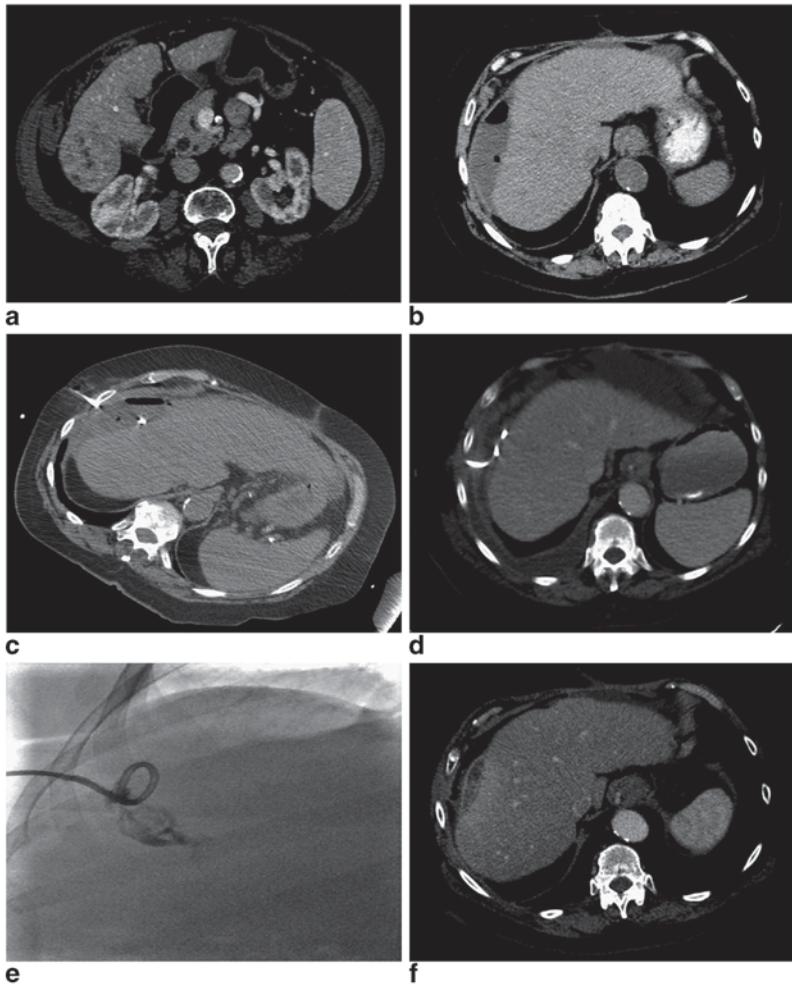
A 68-year-old female with history of cirrhosis secondary to NASH and alcoholism, Child Pugh class A, insulin-dependent diabetes mellitus, and coronary artery disease who presented with a 5.6 cm arterially enhancing exophytic mass in segment 6 of the liver with portal venous washout consistent with hepatocellular carcinoma (a). The patient underwent an uneventful nonanatomic wedge resection, which revealed a well-differentiated HCC without vascular invasion. Her postoperative course was remarkable for postoperative bleeding which was managed with transfusion of two units of packed red blood cells and she was discharged on postoperative day number 8. She presented with increasing right upper quadrant pain approximately 8 weeks after surgery and laboratory evaluation revealed a normal white blood cell count. A CT of the abdomen and pelvis demonstrated a 10.8 × 3.5 cm rim enhancing hypoattenuating fluid collection with an air-fluid level along the right lateral liver (b). CT guidance was utilized for an intercostal approach into the collection and a 10 Fr locking loop drainage catheter
